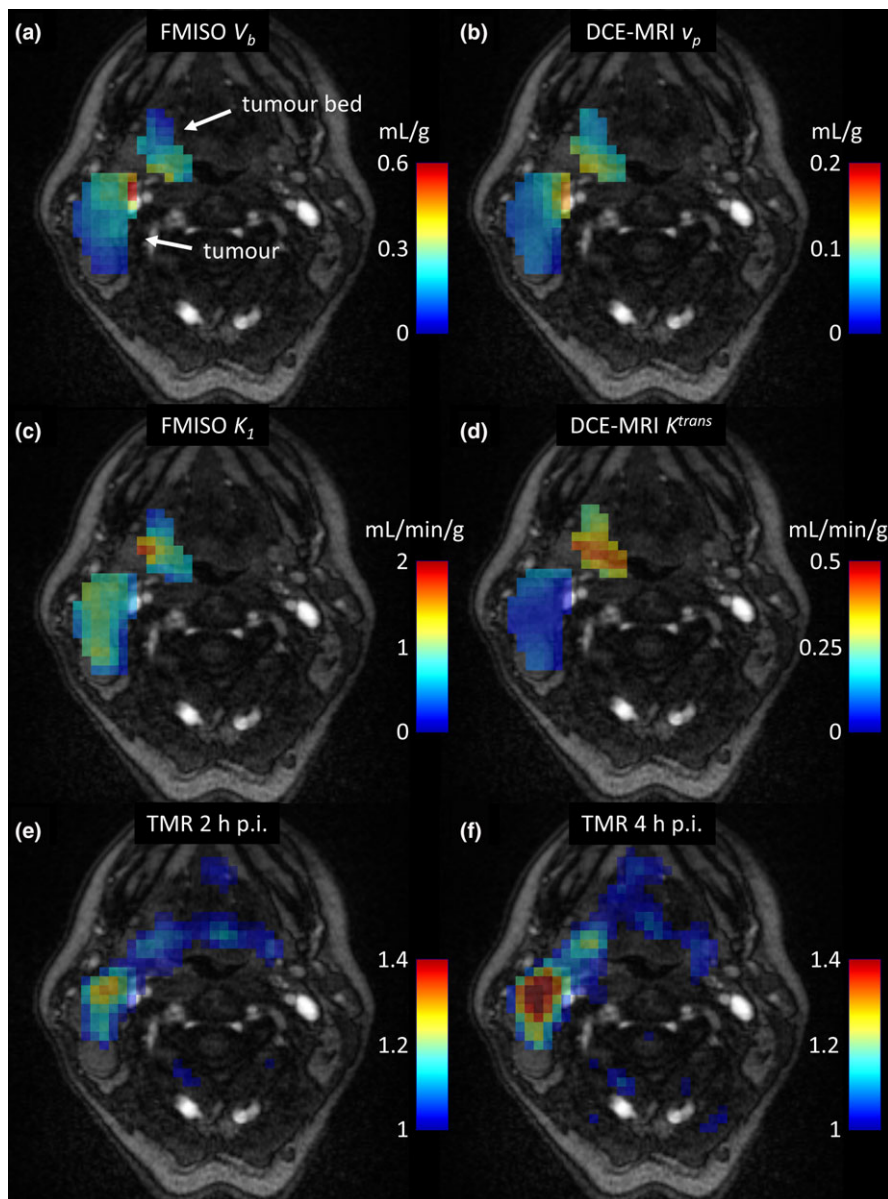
Contrast-enhanced MRI images of the patient P2, overlaid with the FMISO V_b and DCE-MRI v_p parametric images (a) and (b), FMISO K_1 and DCE-MRI K^{trans} parametric images (c) and (d), and TMR maps at 2 h and 4 h post injection (e) and (f). [Color figure can be viewed at wileyonlinelibrary.com]
